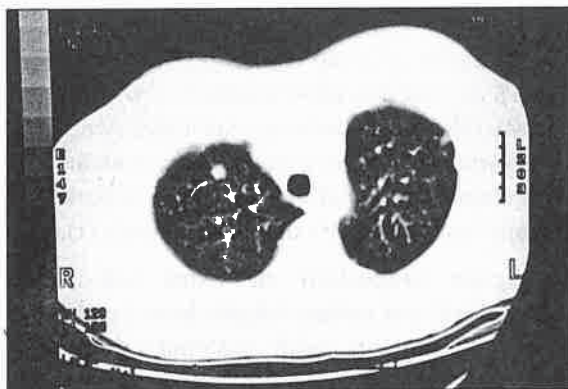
A new thorax CT revealed axillary lymphadenopathies, largest being 1.5 cm in diameter. Parenchymal micronodules were present mainly on the right side. Multiple parenchymal and subpleural nodules were observed, largest being 1 cm in diameter. Findings were interpreted as compatible with miliary tuberculosis.
